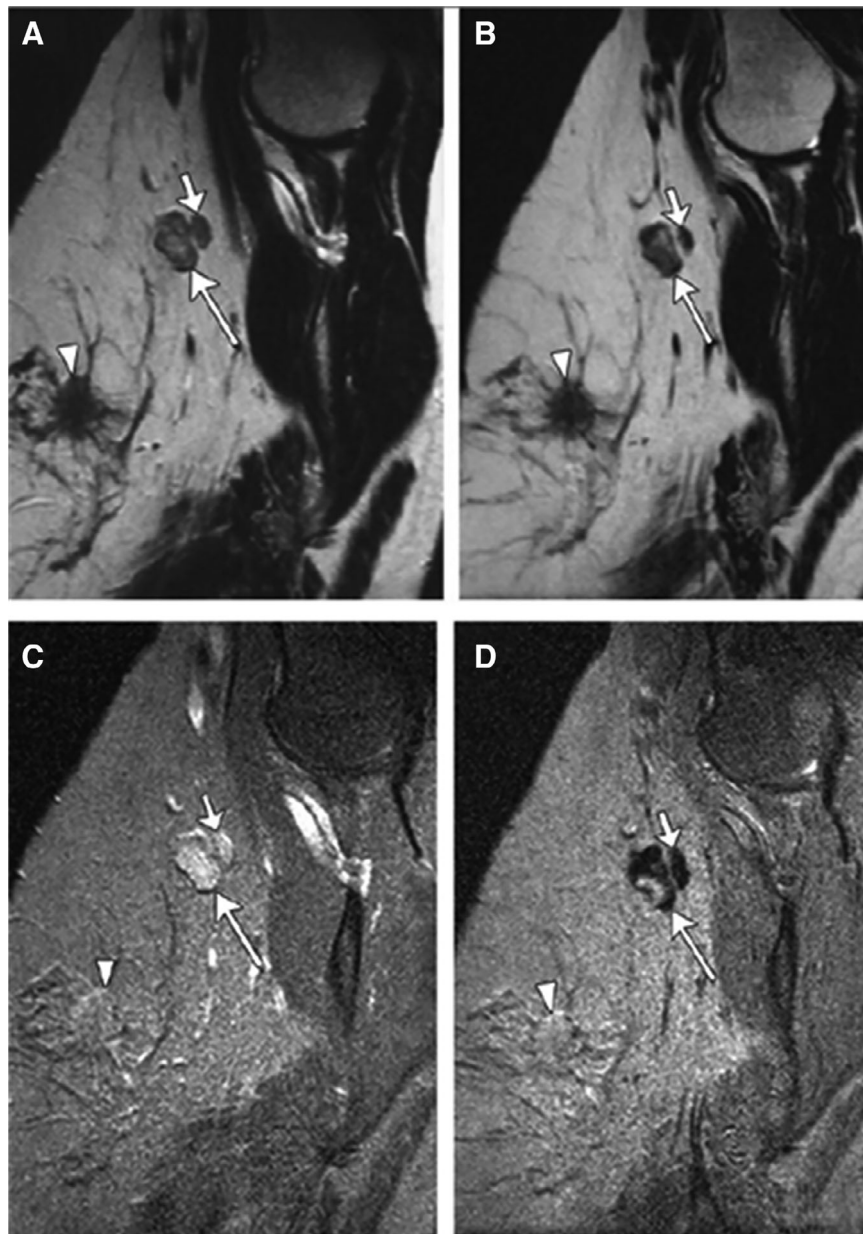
Partial SI decrease in metastatic lymph node in a woman aged 45 years with primary stage pT2N1 tumor. Sagittal non-enhanced (A) and ultra-small superparamagnetic iron oxide (USPIO)-enhanced (B) T2-weighted fast spin echo magnetic resonance (MR) images (7,600/120) as well as nonenhanced (C) and USPIO-enhanced (D) T2*-weighted fast field echo MR images (683/14) of left axilla show a 1.4×0.9 cm metastatic lymph node (large arrow) with partial signal intensity (SI) decrease after USPIO administration. Adjacent nonmetastatic node (small arrow) shows homogeneous SI decrease after USPIO administration. Primary tumor is seen. Reproduced, with permission, from Memarsadeghi et al., Axillary lymph node metastases in patients with breast carcinomas: Assessment with nonenhanced versus USPIO-enhanced MR imaging. *Radiology* 2006;241:367–377 [46]. © 2006 RSNA.
